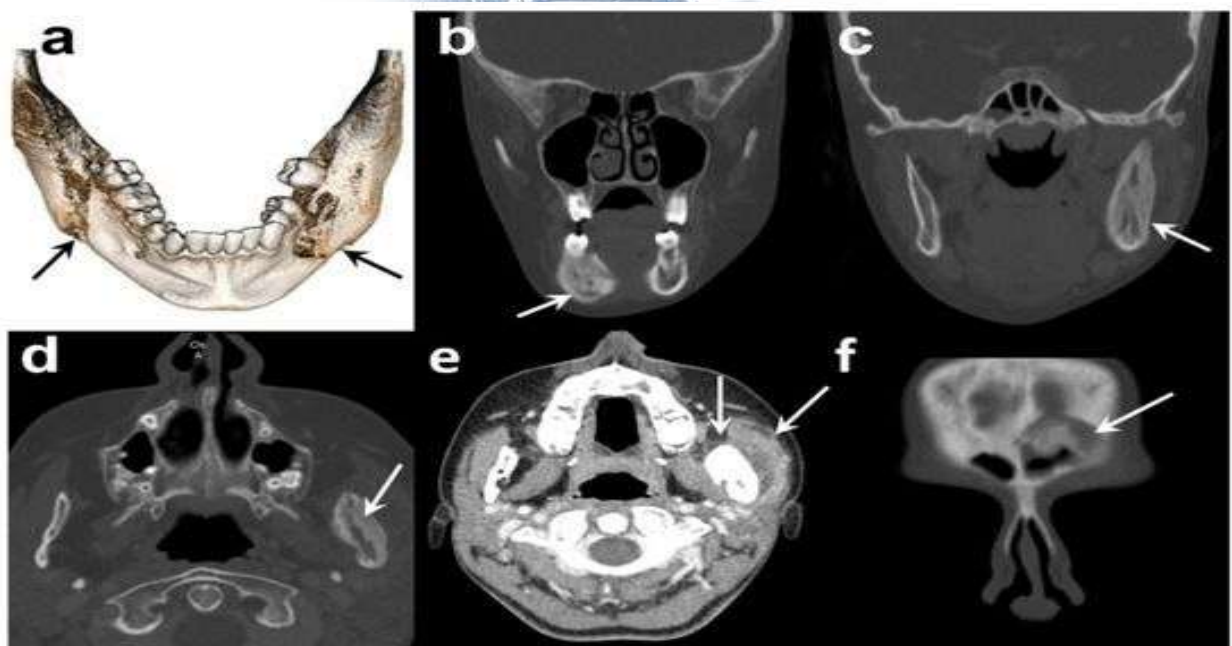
Diagnostic CT scan of the patient: (a) 3D reconstruction of mandible, (b) coronal bone-window section of sclerosis and osteolytic in right corpus of the mandible, (c,d) axial bone-window sections of sclerosis and osteolytic in right corpus of the mandible, (e) axial soft-tissue window section of sclerosis and osteolytic in right corpus of the mandible, (f) coronal soft-tissue window section of sclerosis and osteolytic in right corpus of the mandible.
